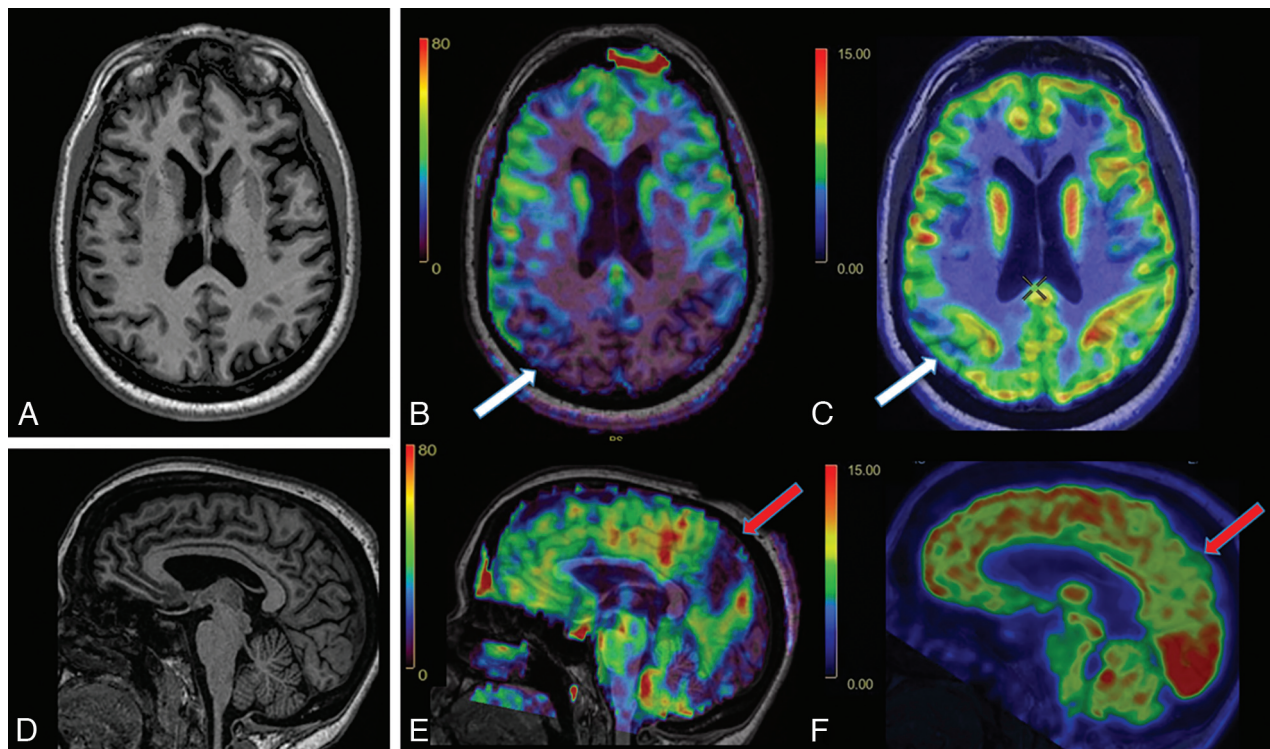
Early-onset AD with *presenilin* mutation. *A*, Axial 3D T1 MPRAGE image shows mild generalized volume loss. Axial CBF image (*B*) and axial FDG-PET image (*C*) show more pronounced decreased CBF than FDG avidity in the bilateral parietal lobes, particularly on the right (*white arrow*), and temporal lobes (not pictured), suggestive of AD. *D*, Sagittal 3D T1 MPRAGE image shows nonspecific volume loss. Sagittal CBF image (*E*) and sagittal FDG-PET image (*F*) show decreased CBF and FDG avidity in the precuneus (*red arrow*).
